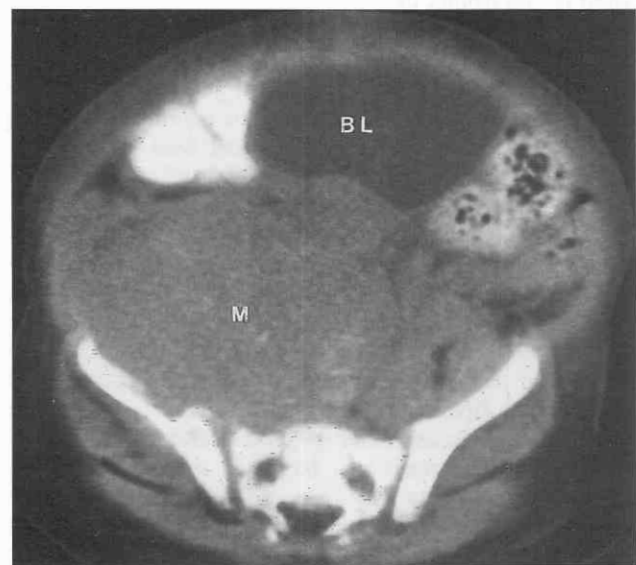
Presacral neuroblastoma. Nonenhanced CT shows a large mass (*M*) of soft tissue attenuation anterior to the sacrum (*S*) and posterior to the bladder (*BL*). The tumor has invaded the right sacroiliac joint and the right iliac wing.
